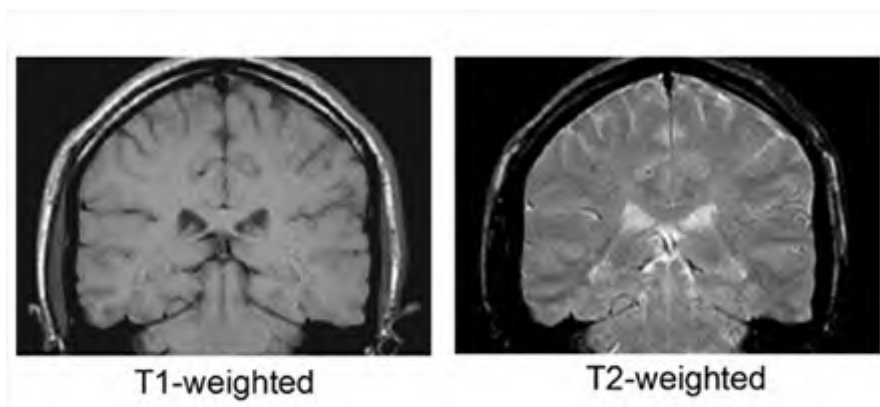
Comparison between T_1 -weighted MRI and T_2 -weighted MRI.
